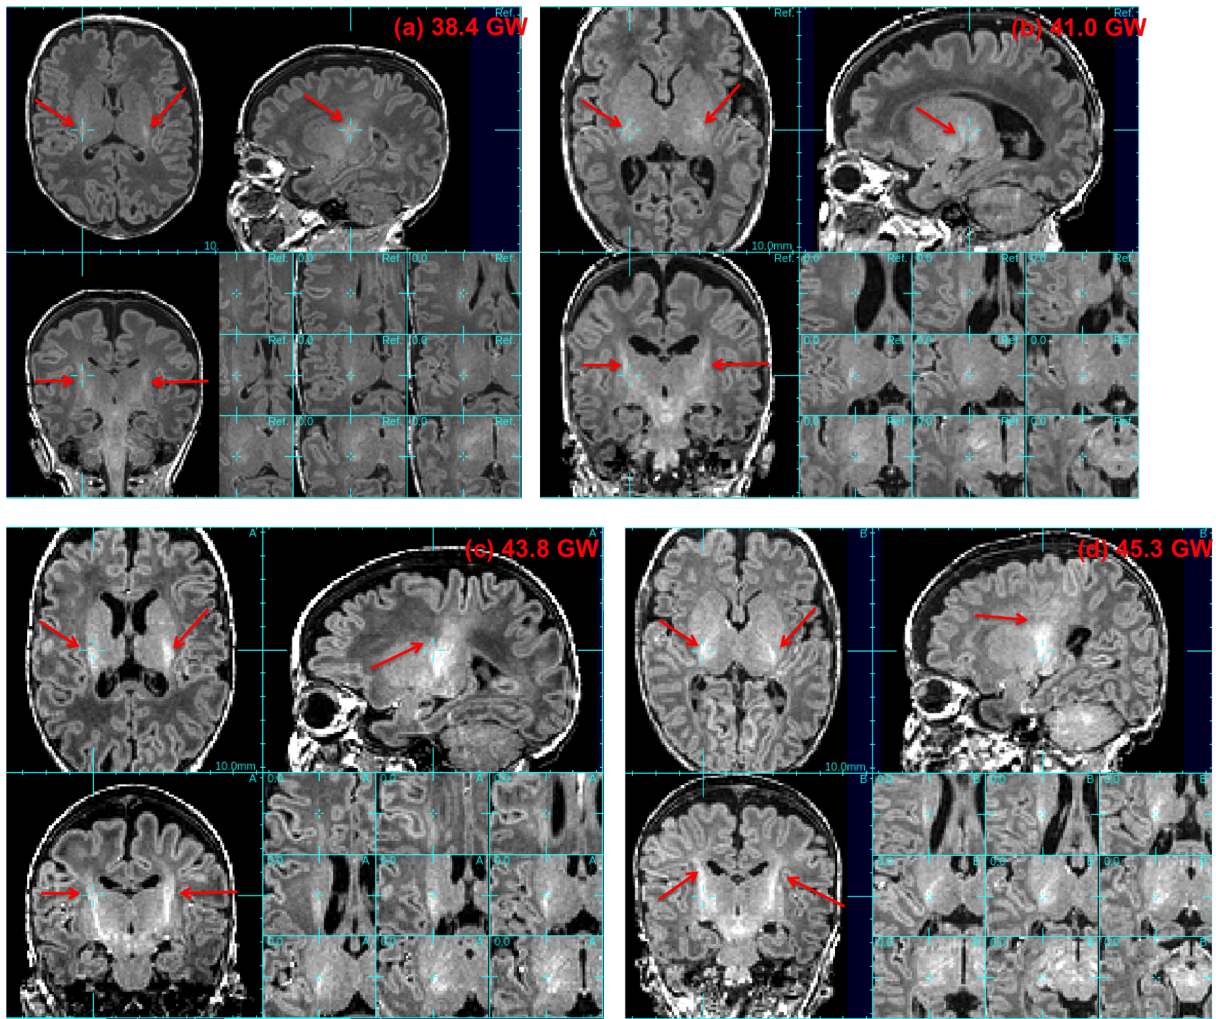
WM myelination progress shown in T1W MRI from Vancouver dataset. Gestational ages are marked on each scan. Red arrows: WM myelination and its progress.
